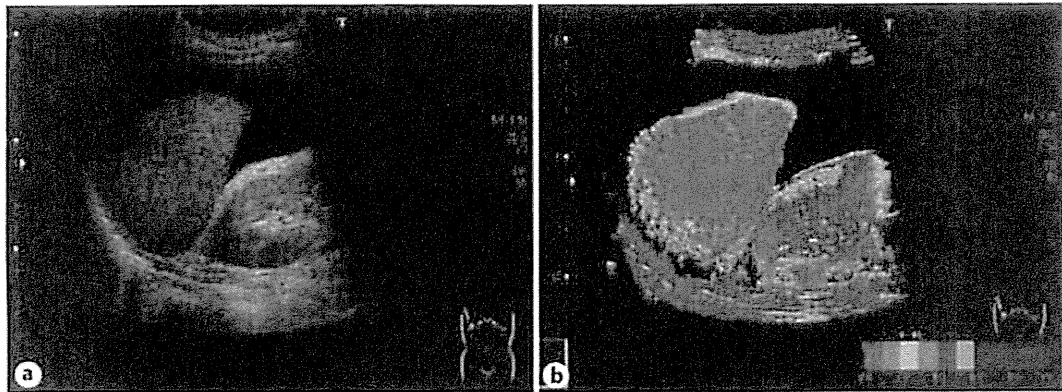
Ultrasound images of case 1 taken in April 2009. a B-mode ultrasound image. b Arrival time parametric image. Red is dominant in the entire area of the arrival time parametric image of the liver.
